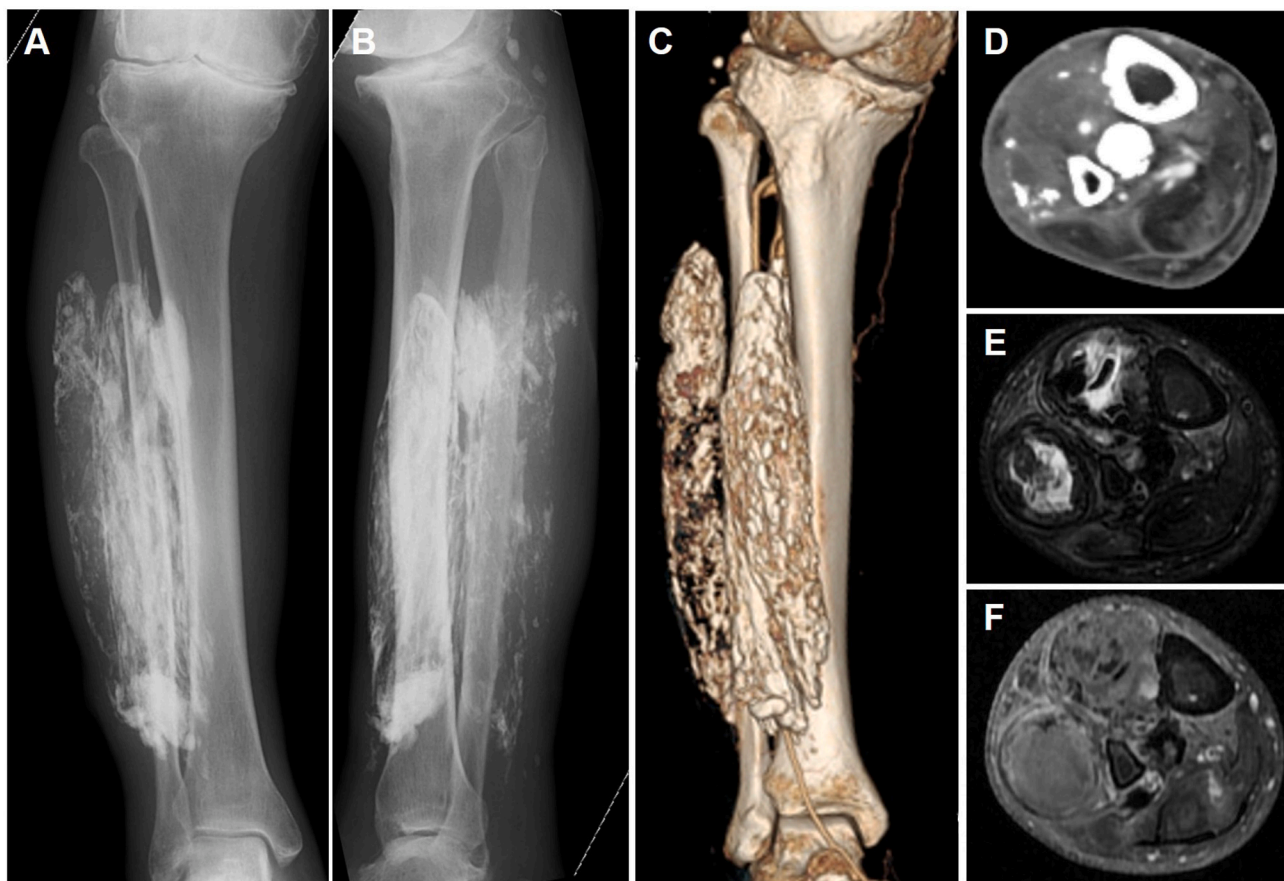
Plain radiography of the right lower leg. Frontal view (A) and lateral view (B). 3D-CT image (C). Axial image of enhanced CT shows eggshell-like calcification of anterolateral side and bulk calcification in tibiofibular area (D). Axial T2-weighted image with fat suppression shows high-signal area reflecting fluid collection (E). Coronal gadolinium contrast image shows no significant enhancement (F).
